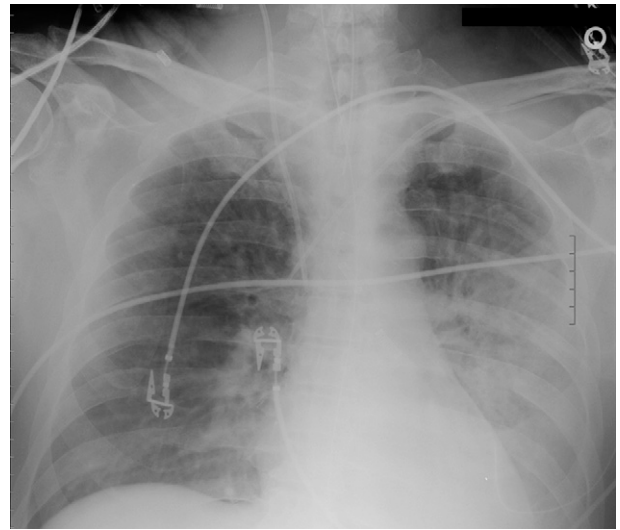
Chest radiograph 3 days after initiation of phentolamine infusion.
